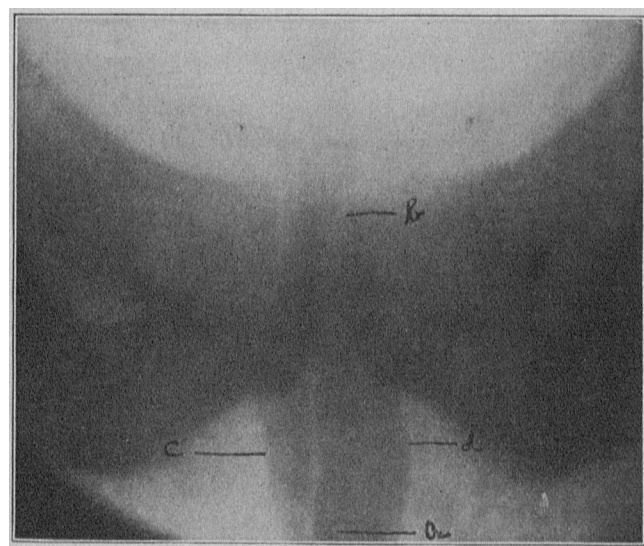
Roentgenogram showing calculus in urethra extending from *a* to *b* and from *c* to *d*.
